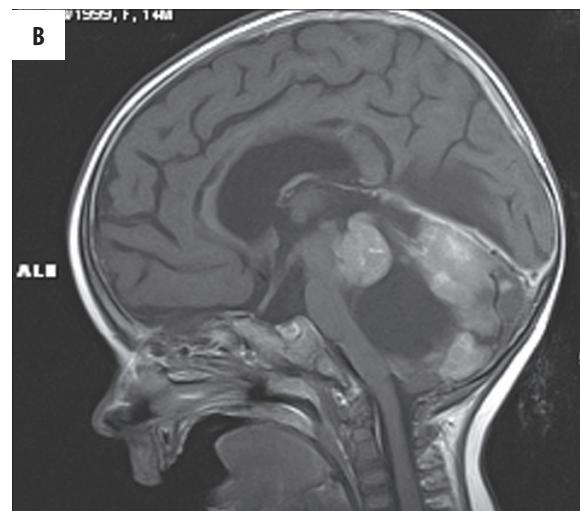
MRI of the retrospectively reviewed 14-month-old girl.
